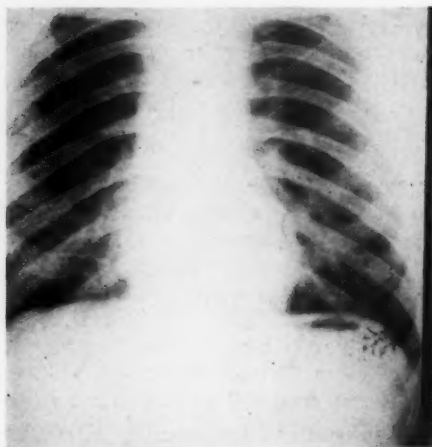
Six-foot roentgenogram, August 16, 1939, one month postoperatively showing narrowing of the superior mediastinum, and a reduction in the size of heart towards normal.
